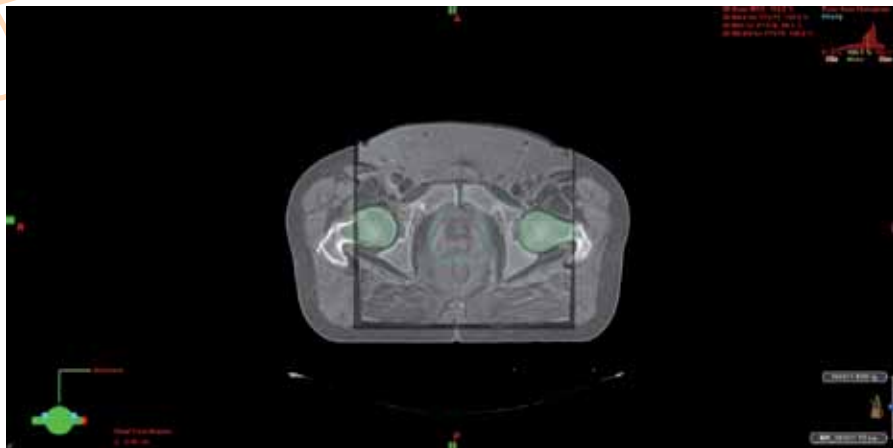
An example of MRI and CT image registration.
